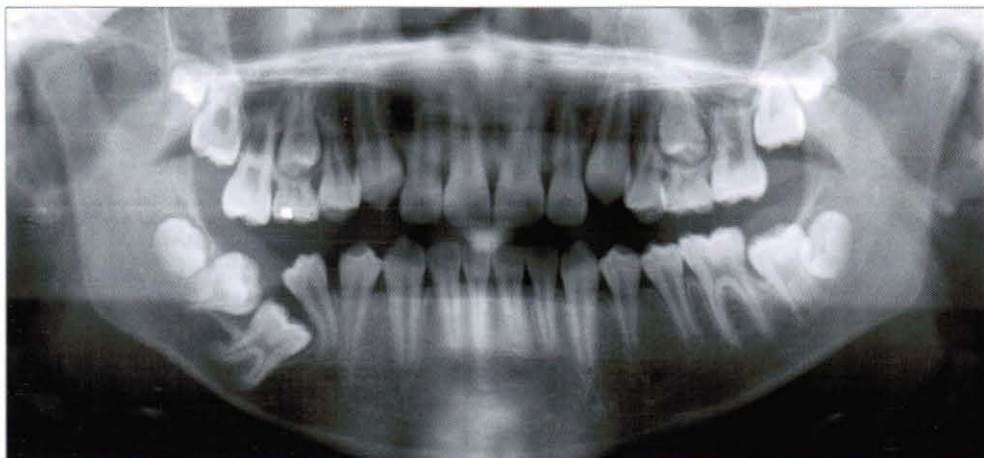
Pre-treatment panoramic radiograph (2004, 2,17)
